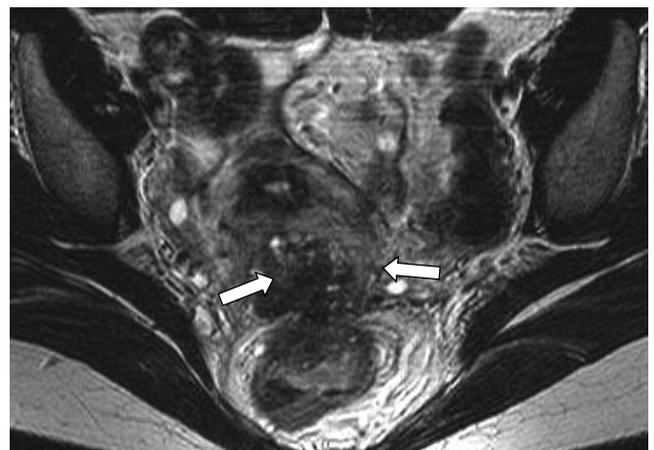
Magnetic resonance image (axial image, T2-weighted sequence) showing the nodule clearly visible within the myometrium (arrows), corresponding to focal adenomyosis, which is infiltrating the posterior rectovaginal wall. Hemorrhagic foci are clearly depicted with T1- and T2-weighted sequences and correspond to endometrial glands within the endometriotic nodule (same patient as Figure 2).
